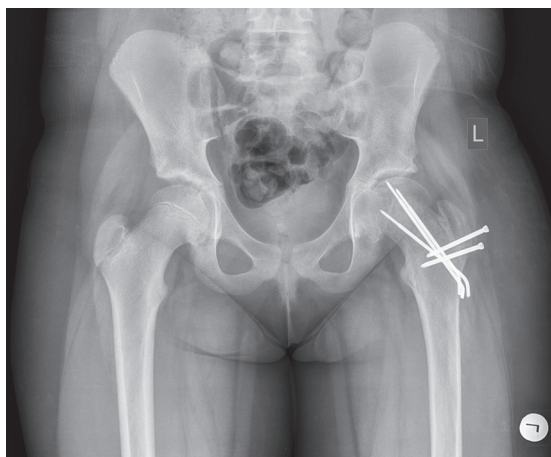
X-ray of hip joints, female patient, after surgery: restored anatomical relations of epiphysis and femoral neck
